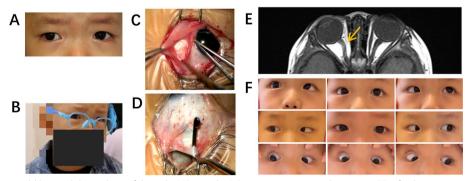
Case 4: A 2-year-old boy with hypoplasia of the right MR muscle. A Preoperative picture showing 40 PD of right exotropia and 5 PD right hypertropia in the primary position. B The patient presented with a clinically significant left face turn. C, D Surgeon's view showing absence of MR muscle (C), while other EOMs, such as the SO muscle (D), were thin in the right eye. E Postoperative MRI scans revealed the absence of the right MR muscle(arrow). F At 8 months after surgery, the patient demonstrated orthophoria in the primary position, along with vertical alignment abnormalities in upgaze
